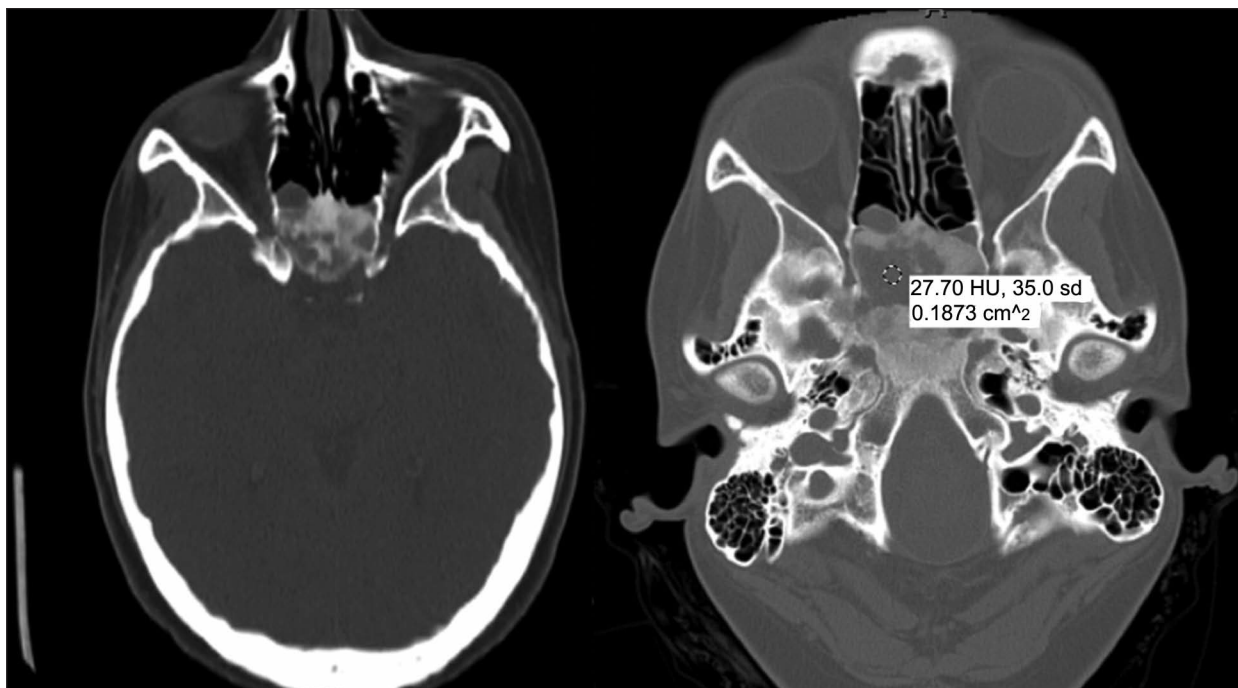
A: Axial CT scan without contrast enhancement demonstrating acute cystic degeneration that occurred at the time of presentation during the patient's pregnancy demonstrating worsened optic canal narrowing that had become symptomatic. B: Axial CT image without contrast enhancement showing the Hounsfield Units of the area of ACD, which confirm that the hypodense region is fluid and not fibrous bone.
